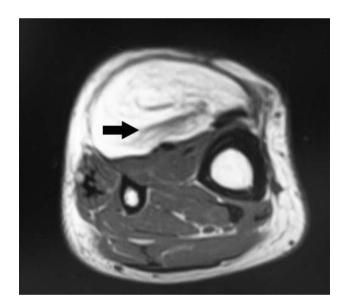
Example of amorphous, non-fatty areas within the lipomatous tumor. The image presents a case of lipoma in the lower leg of a 67-year-old female patient. The amorphous, non-fatty areas were detected in the T1-weighted image (black arrow).
